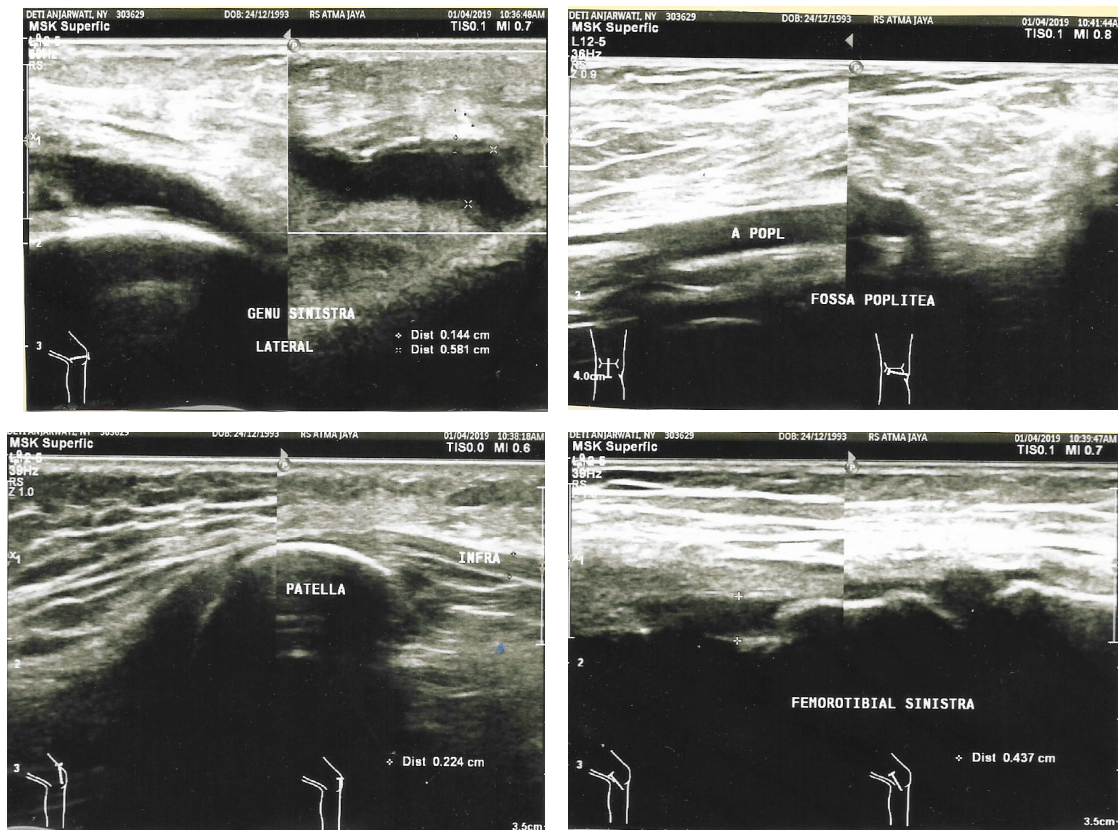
Ultrasound of the genu sinistra which showed synovitis with fluid volume of 1-2 cc on recessus lateral genu sinistra
